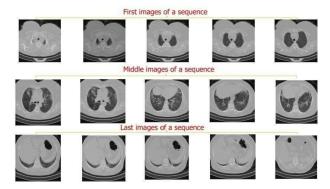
This figure presents some of the first, middle, and final images of a patient's CT scan sequence. It is obvious from the images in the first and the last images, inside the lung is not observable.
